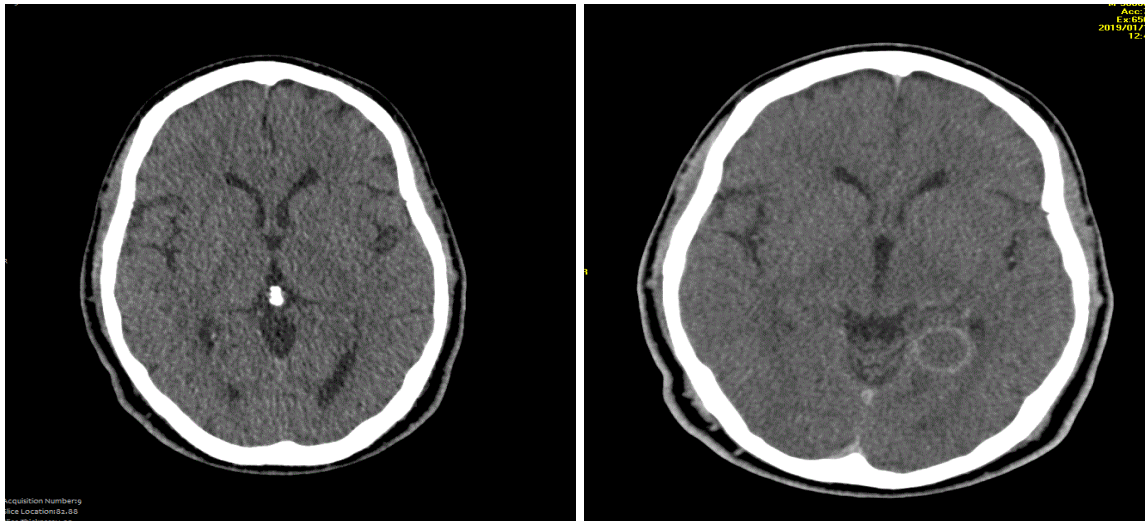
Brain CT scan without and with injection in axial section showing a spontaneously hypodense left parietal lesion enhancing peripherally after PDC injection (cocardial appearance) in favor of a tuberculoma
